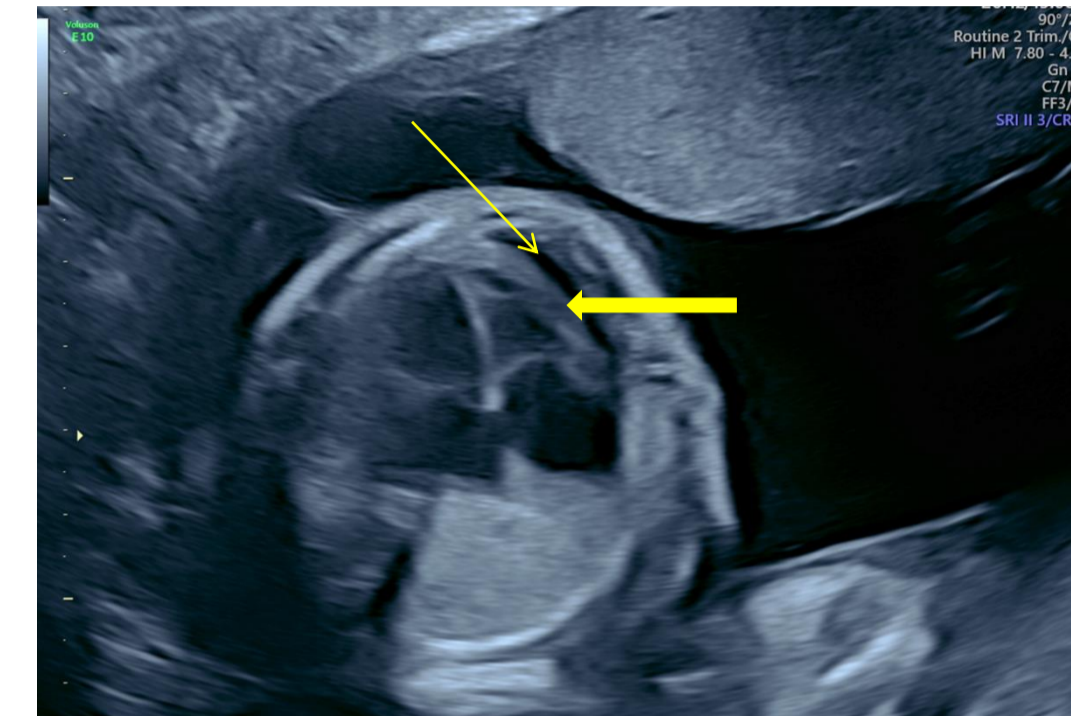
Fetal cardiac ultrasound showing pericardial effusion (thin arrow) and thickened right ventricular wall (thick arrow)
